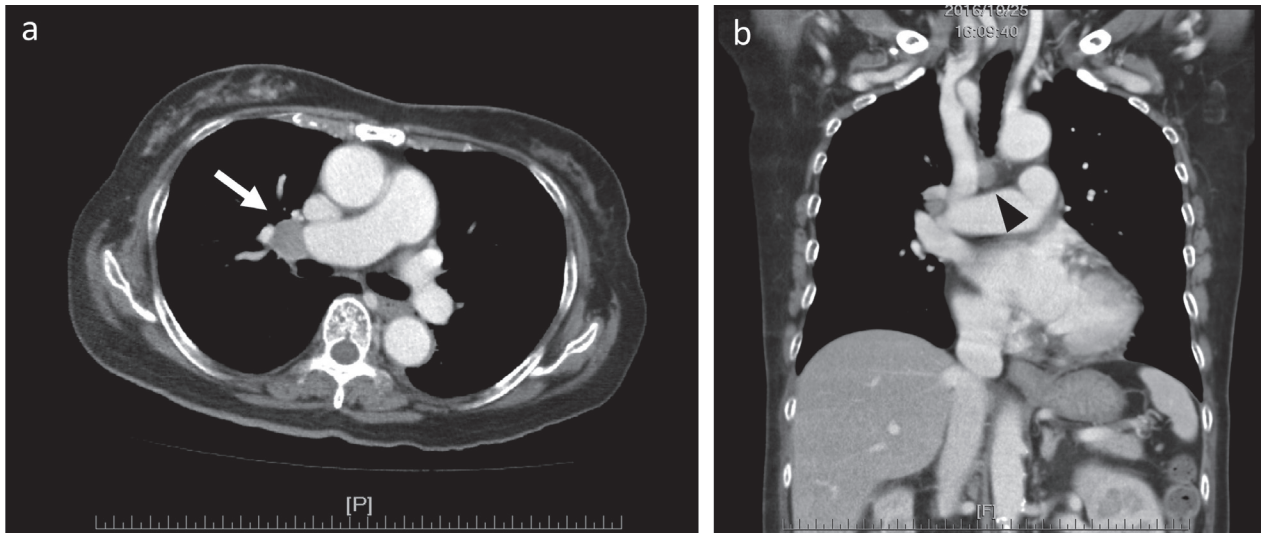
Chest CT showing an enlarged lymph node at the right pulmonary hilum (a, arrow) and right lower paratracheal area (b, arrow head).
